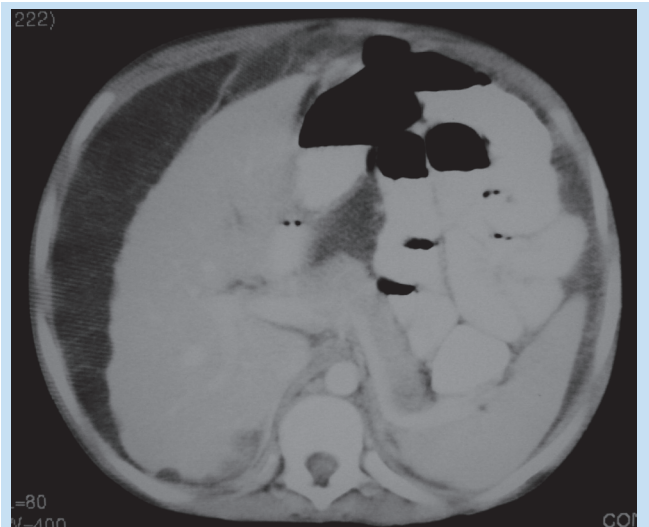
Axial contrasted CT scan of the abdomen shows intraperitoneal spillage with multiple small cysts compressing the liver and resulting in a scalloped contour.
